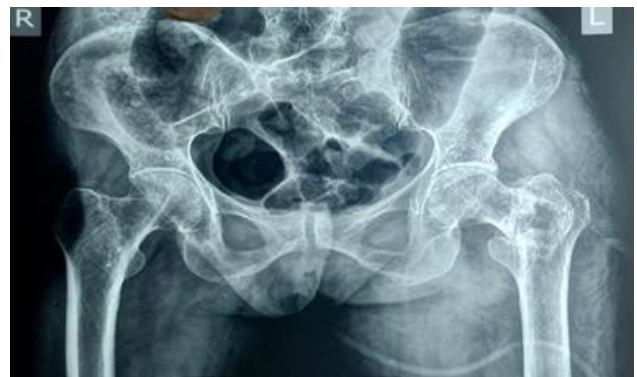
Post op X-ray of (case 2).
